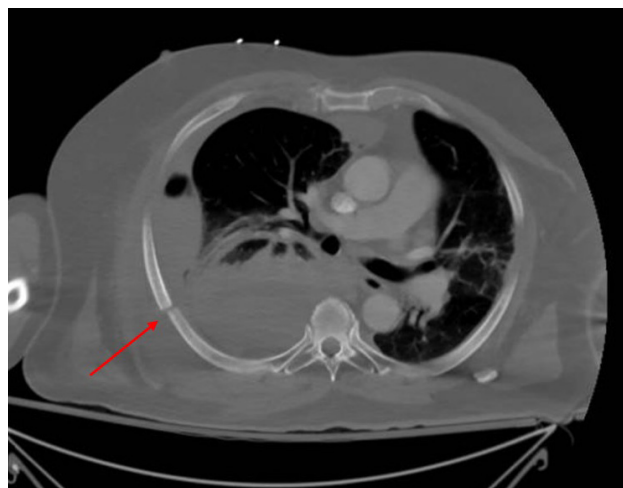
Contrast-enhanced computed tomography of the chest. The arrow points to the right seventh rib fracture. A large pleural effusion is also seen
